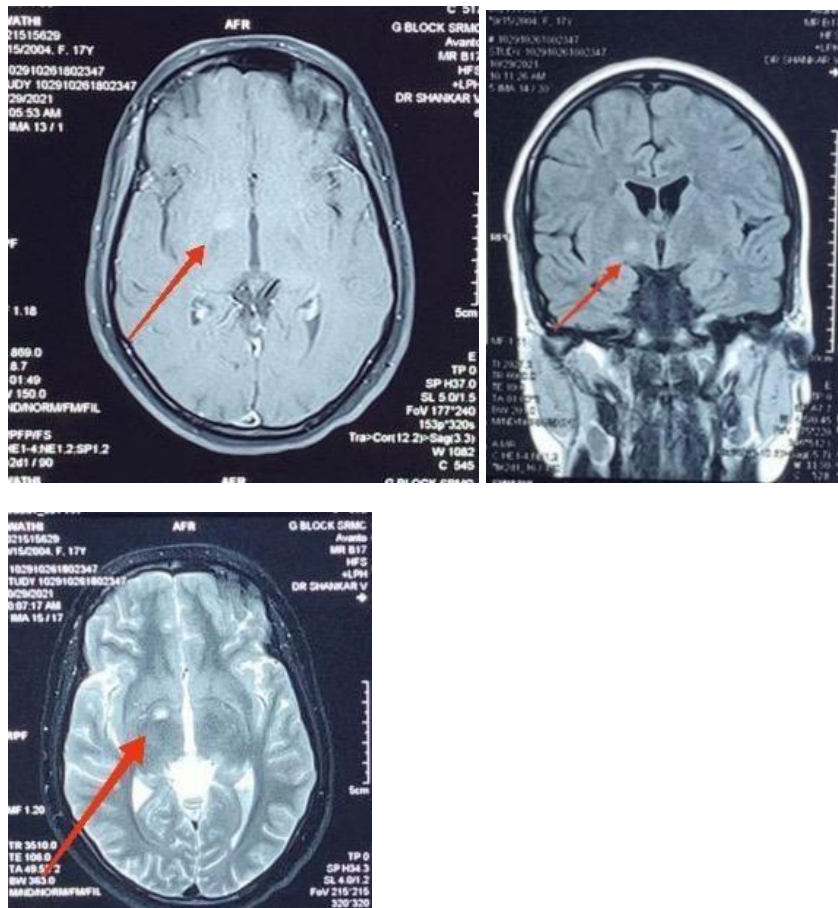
MRI Brain showed demyelination changes in right thalamo capsular region
